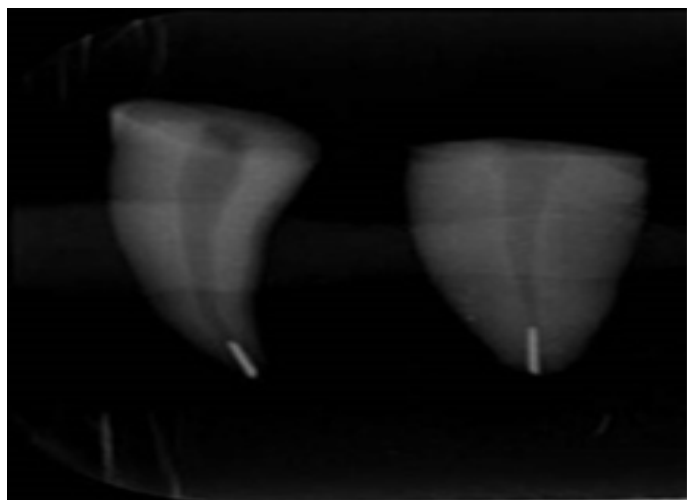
Radiographic image of broken file in the apical part of root canal
